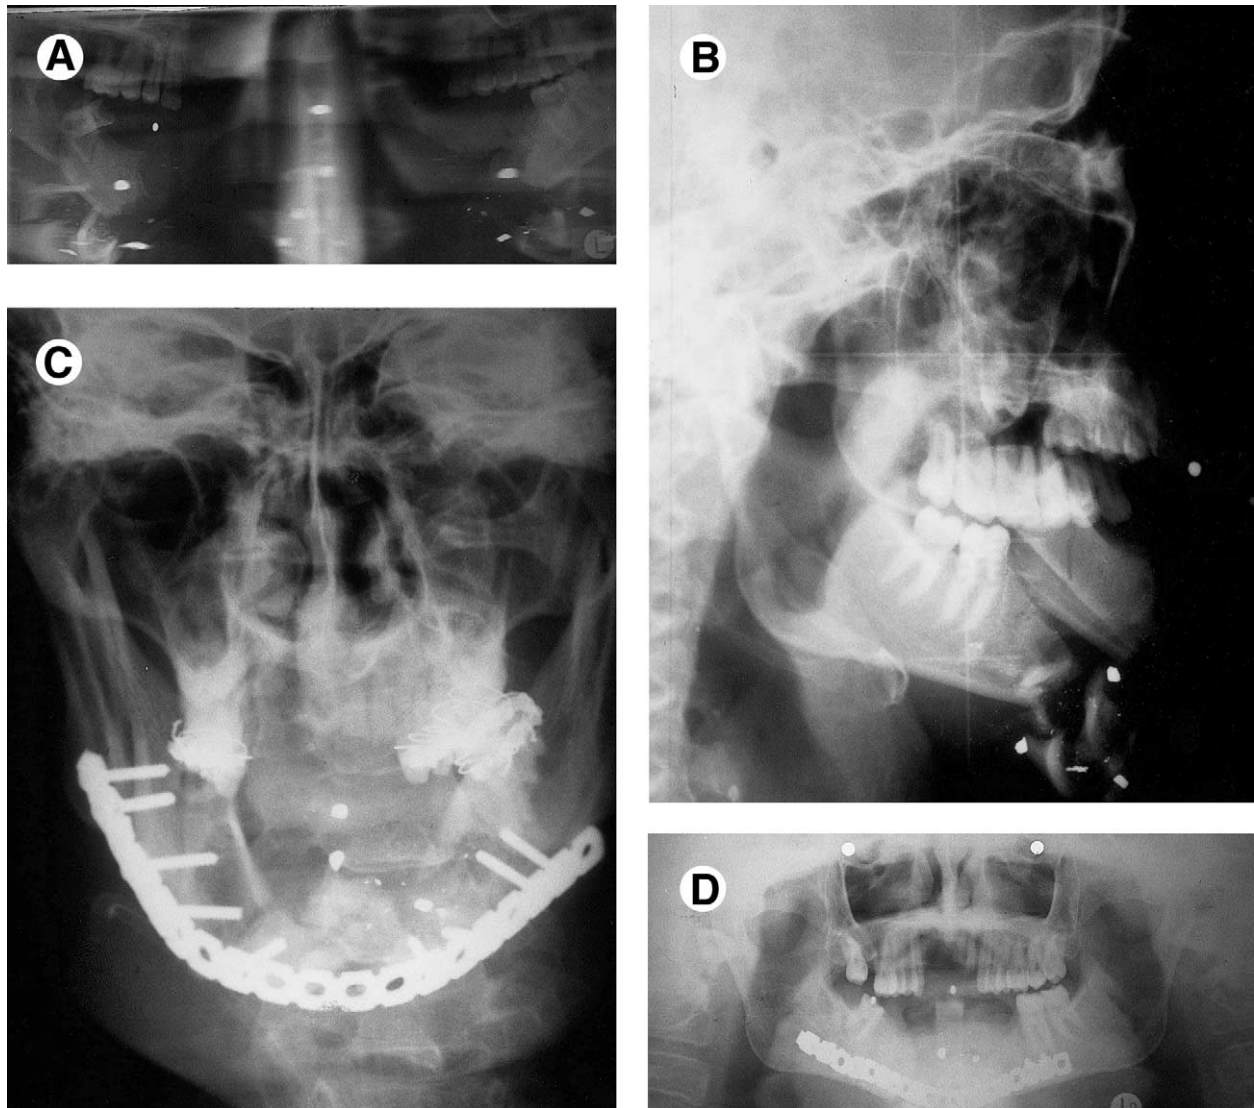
A, Orthopantomogram of a patient with an extensive gunshot wound to the anterior mandible; bone appears to be lost anteriorly. B, Lateral skull radiograph reveals fragments displaced inferiorly into the neck. C, D, Segments were located intraoperatively and secured to an AO 2.7 reconstruction plate with screws to restore continuity obviating bone grafts. This is a typical case where primary management of both hard and soft tissues is indicated.
